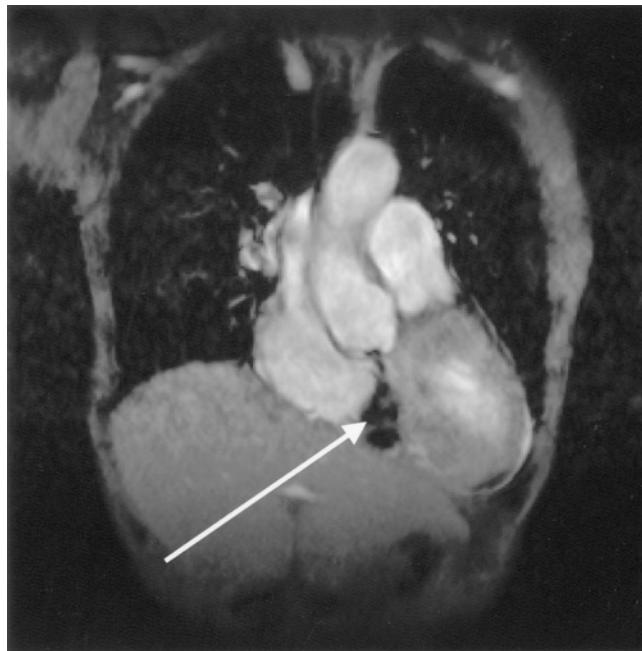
Cine MRI image. An abnormal flow drained from aorta into the RA is seen (arrow).
